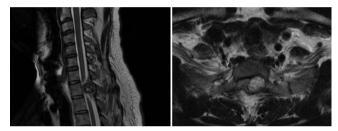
Sagittal and axial magnetic resonance imaging showing osteochondroma located at T1 vertebra
